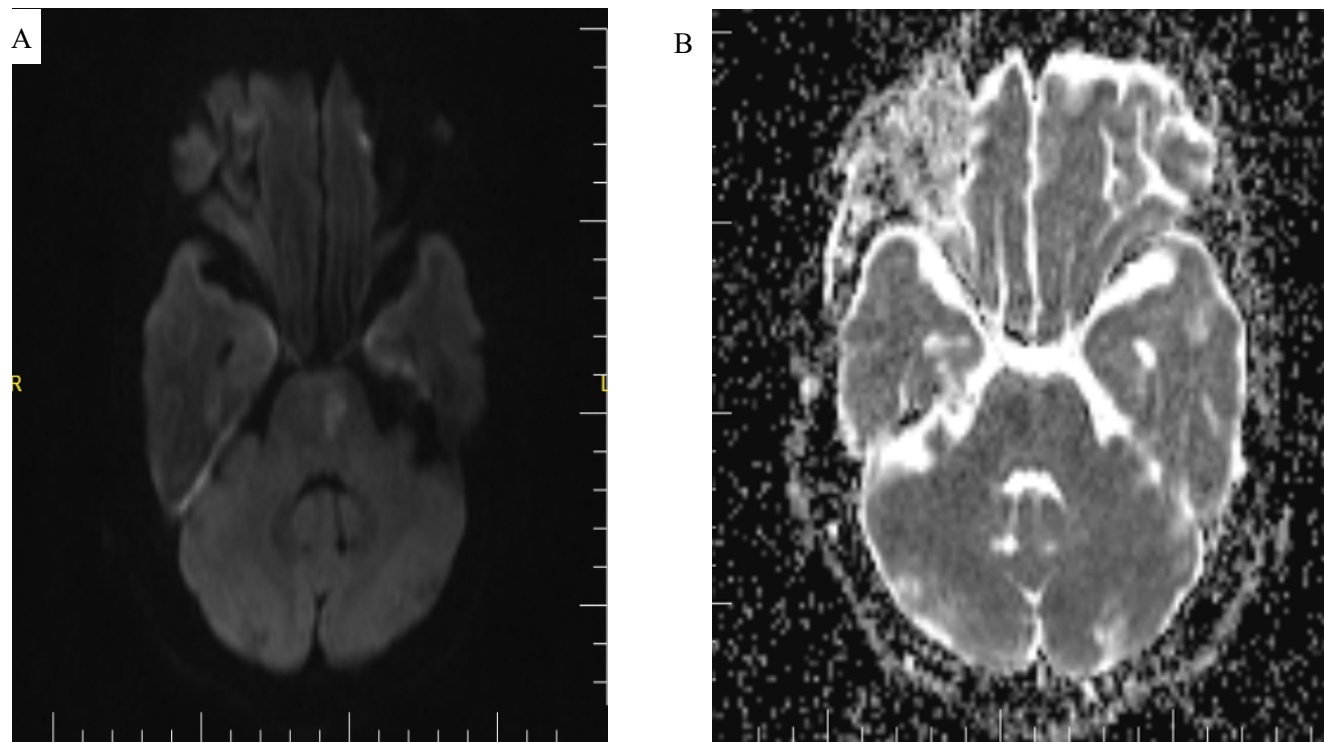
(A-B) Brain MRI showing hyperintensity in the DWI and hypointensity in the ADC on the ventral part of the pons consistent with acute infarction.
